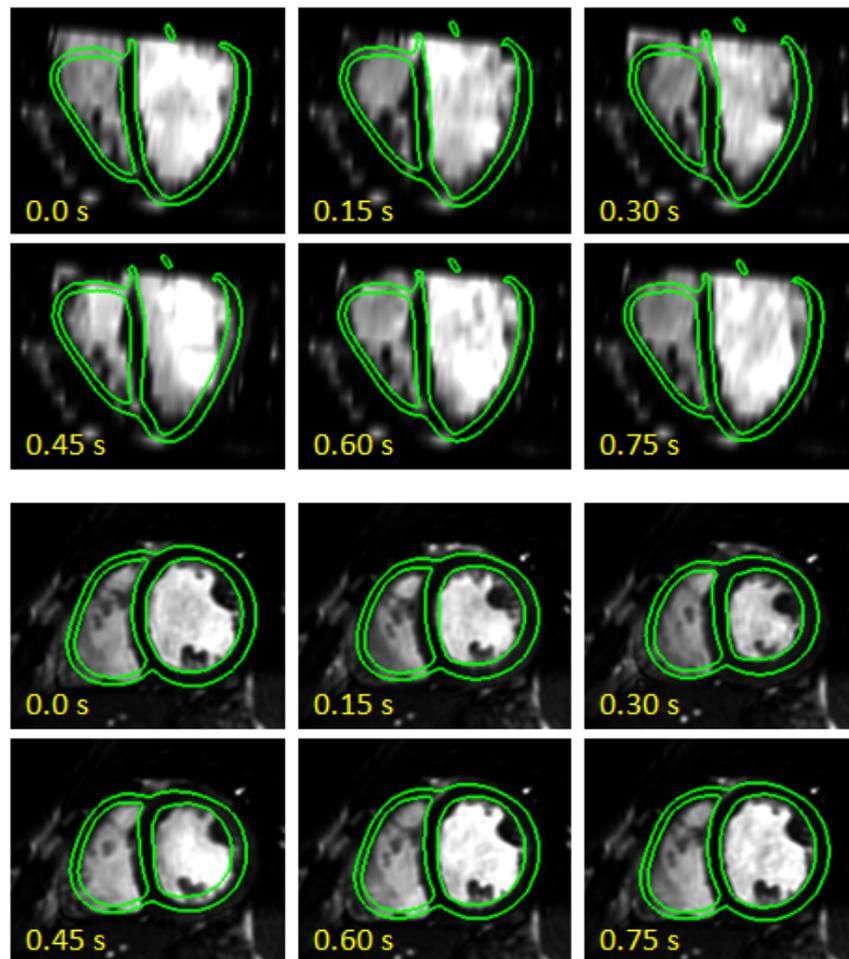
Personalization results for the patient with largest contraction. Long-axis (top) and short-axis (bottom) slices show MRI images and personalized model at various time steps throughout one heart cycle [98].
